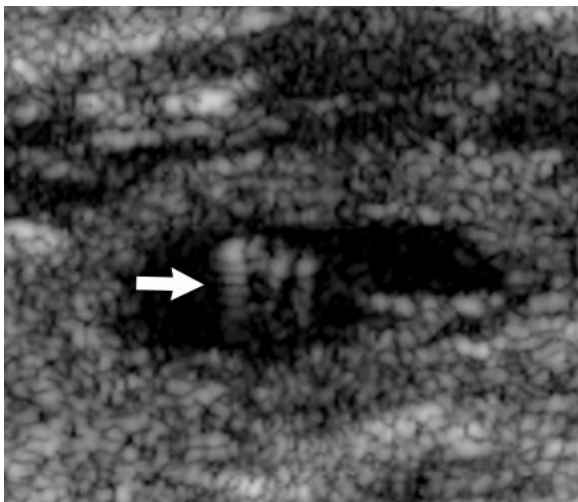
Benign thyroid nodule in a 51-year-old woman. Transverse sonogram of the right lobe of the thyroid shows a colloid nodule with a ring-down artifact (arrow), a finding indicative of inspissated colloid calcification.
